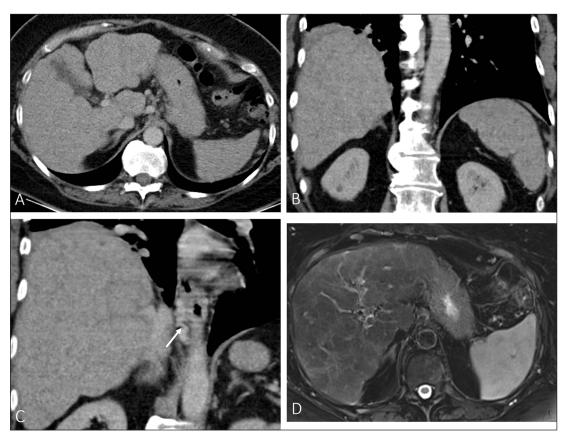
Imaging examinations four years later: Axial (A) and coronal (B and D) contrast-enhanced CT of the abdomen in the portal venous phase. (A) shows a nodular contour of the liver with a relative enlarged caudate lobe. (B) shows multifocal hypodense splenic lesions. (C) demonstrates esophageal varices (black arrow). Axial FS T2-WI (D) shows a heterogeneity of the liver parenchyma with multiple relative hypointense lesions diffuse throughout the liver.
